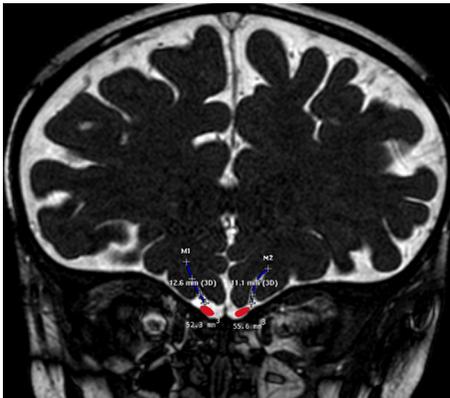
Olfactory bulbs (red area) and olfactory sulcus (blue line) are shown on coronal three-dimensional (3D) balanced fast-field echo magnetic resonance imaging. A semi-automatic measurement of the olfactory bulb volume using manual segmentation and multiplanar reformatting on the 3D workstation. To minimize the possibility of errors in volumetric measurements, the images were magnified as much as possible. The volumes are given in mm³, and the line measurements are given in mm.
